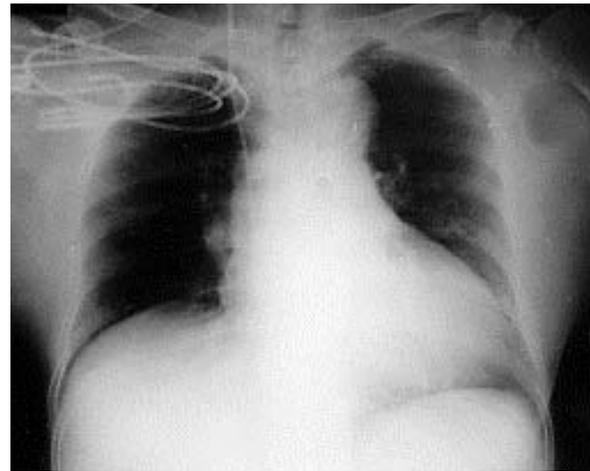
Chest radiograph after coronary angiography
